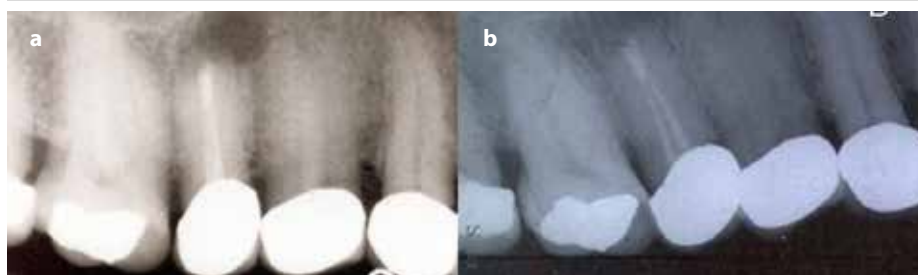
(a) Immediate post-surgical radiograph for UR5 with MTA retrograde restoration. (b) 12 month post-operative radiograph showing healed lesion.
